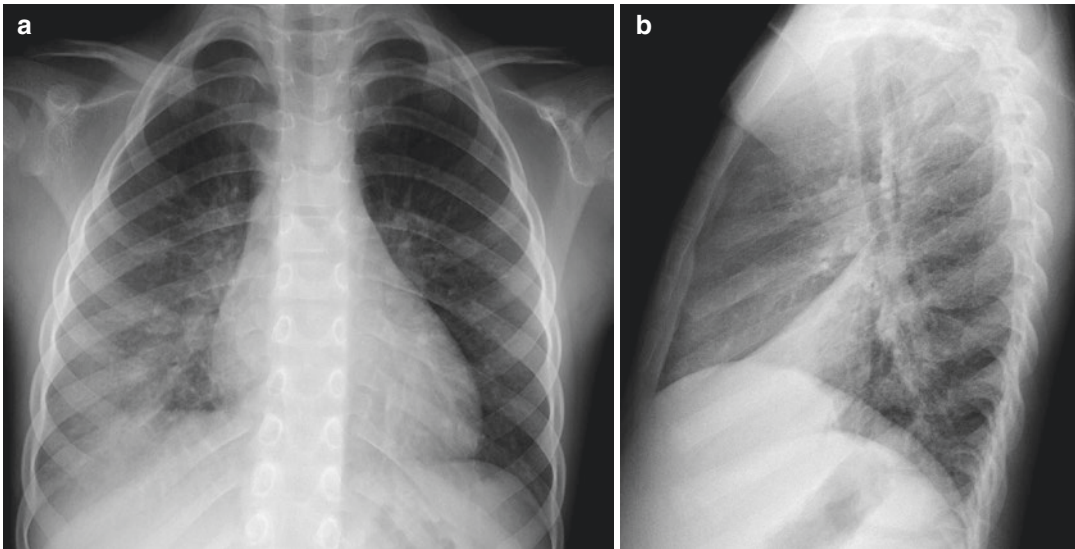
Frontal (a) and lateral (b) chest radiograph demonstrating right lower lobe pneumonia in a 6-year-old male presenting with cough and fever
